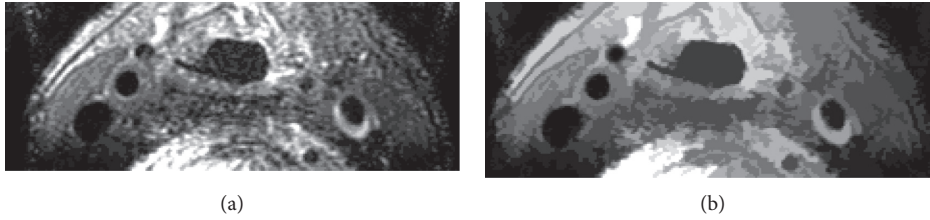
(a) The original MR image. (b) The result of morphological reconstruction.
